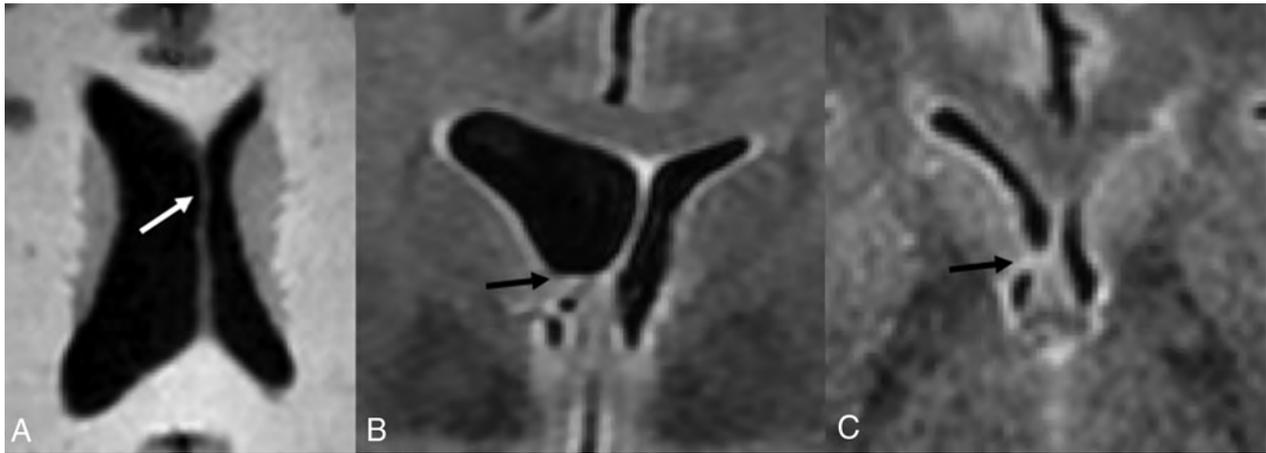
Lateral ventricular asymmetry in a 56-year-old woman referred from a separate institution for the management of a suspected intraventricular mass. A, Axial T1-weighted MR images demonstrate asymmetric enlargement of the right lateral ventricle. There is mild bulging of the septum pellucidum (*white arrow*), which prompted careful evaluation of the lateral ventricular outflow. Coronal (B) and Axial (C) T2-weighted FLAIR images show no intraventricular mass but rather coaptation of the ependyma covering the caudate nucleus and fornix (*black arrow*). These imaging findings causes partial outflow obstruction and unilateral hydrocephalus. This remained stable on multiple subsequent follow-up MRIs and was favored to represent coarctation versus scar.
